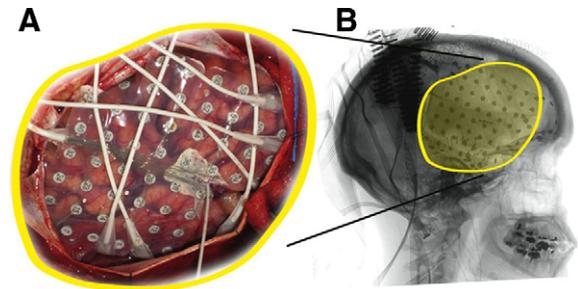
Example of an implanted subdural grid in patient AMC3. (A) Subdural grid placed over frontoparietal areas. (B) Lateral radiograph indicating the position of the grid.
